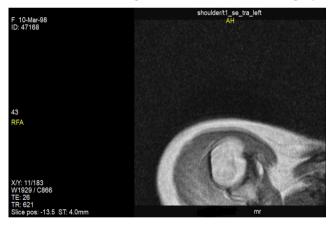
MRI scan of the right shoulder before the surgery
